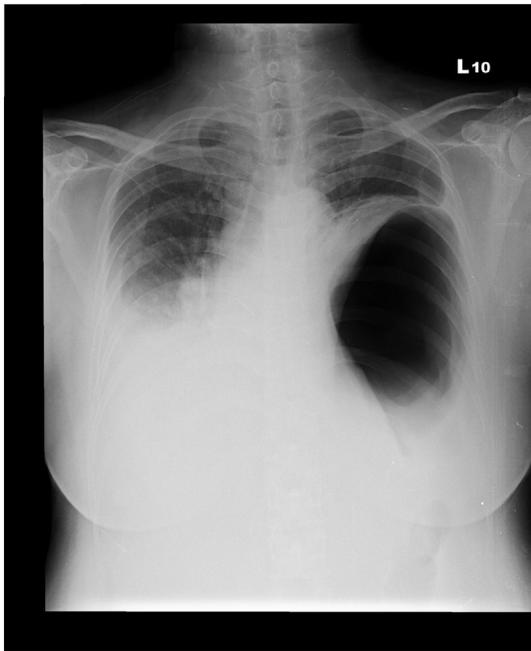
Chest radiography showed trachea deviation to the right side with intrathoracic stomach, mimicking a left-side tension pneumothorax.
